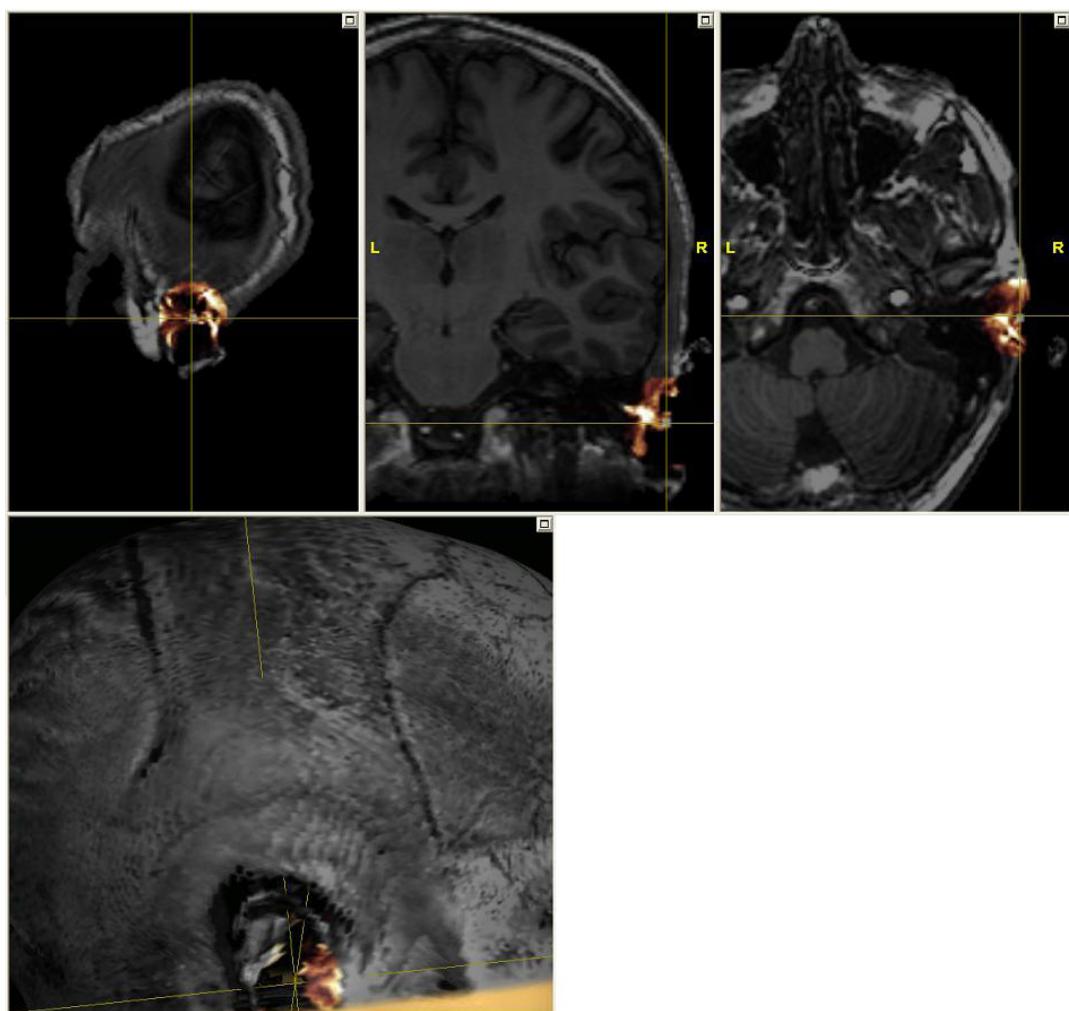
Heat colormap: Location of the right ear landmark in MR images and 3D head
